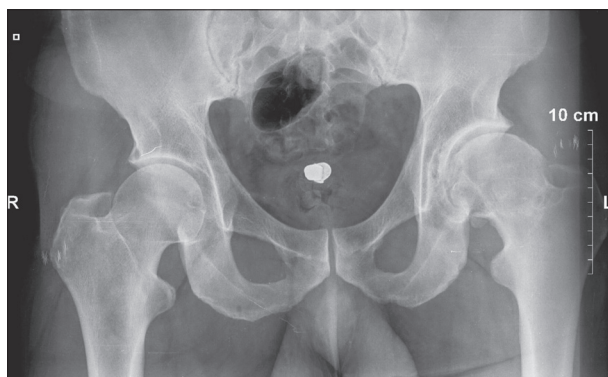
X-ray of the pelvis showing the foreign body
